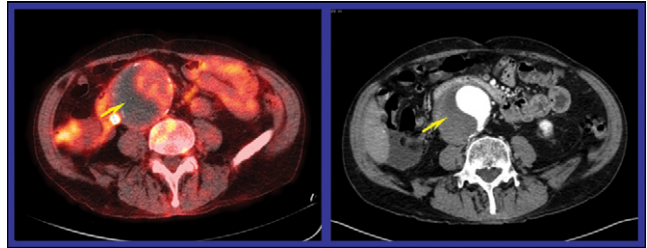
In this patient from the same study as Figure 16, uptake of ^{18}F -FDG in a 7.2-cm ascending aortic aneurysm with a cold region within the vessel on PET (left) suggested the presence of thrombus, as confirmed on contrast CT (right).
